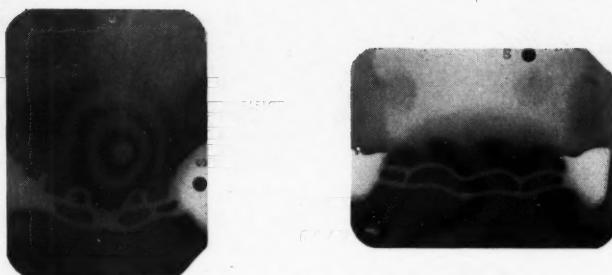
Roentgenograms showing reinforcement frames.
